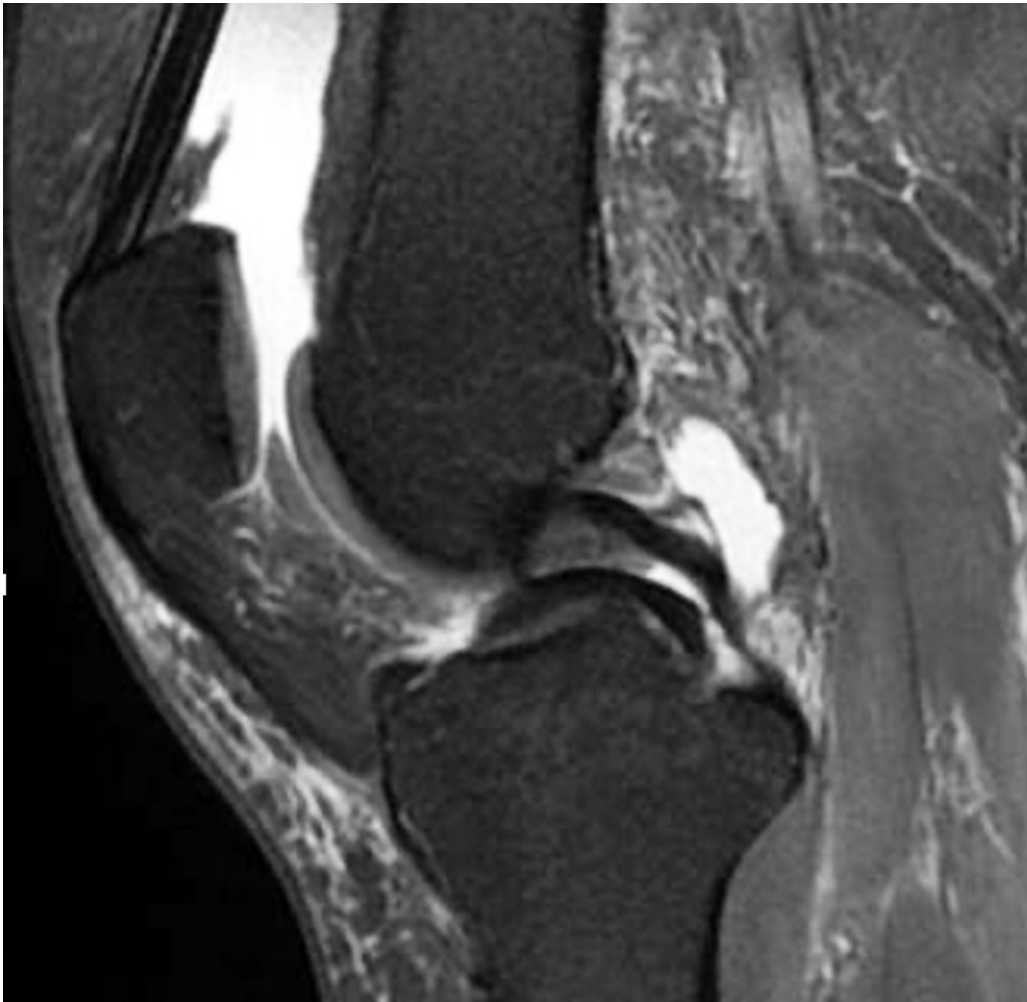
MRI of the knee, sagittal plane, showing a folded bucket-handle tear in the medial meniscus. Photo: Martina Hansens Hospital
